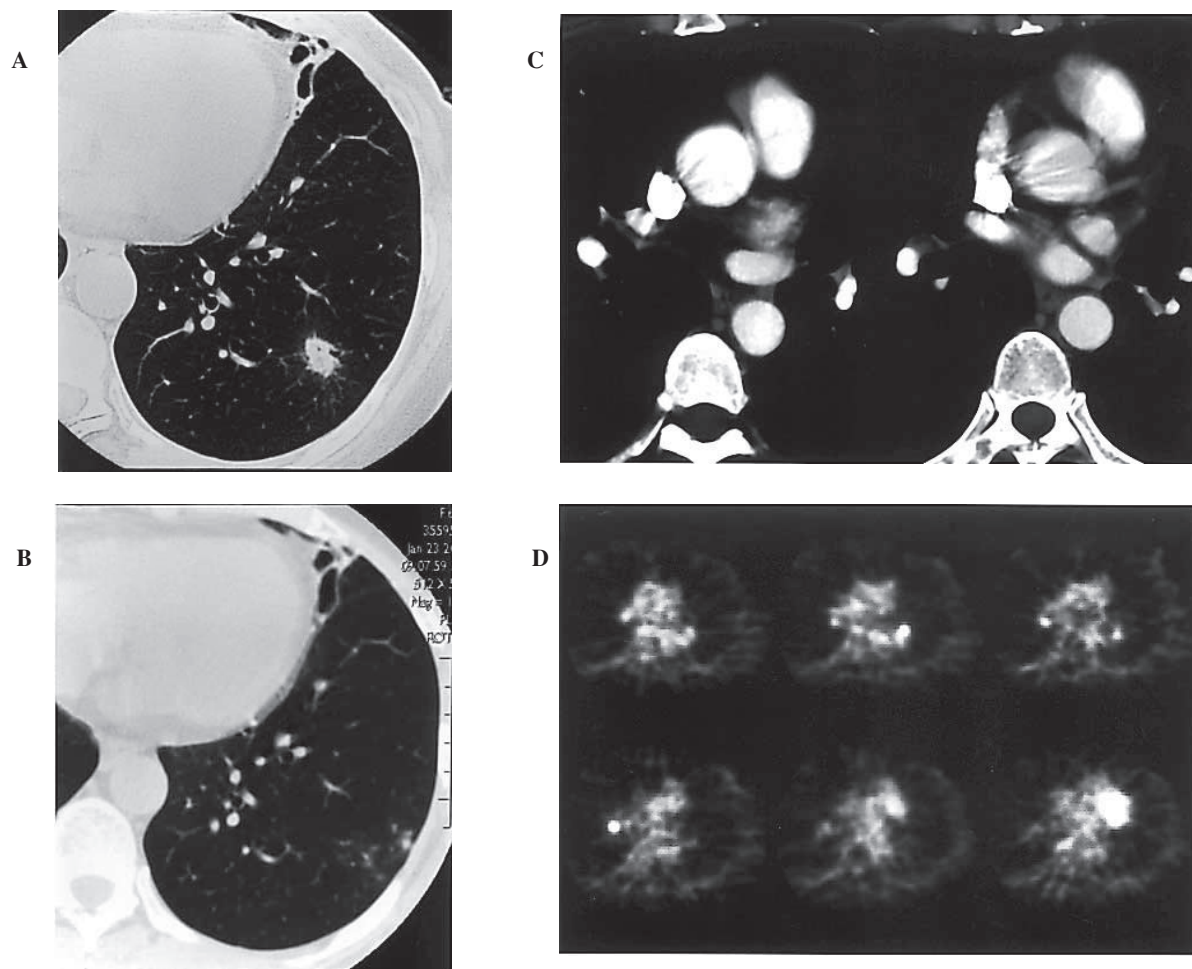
A 64-year-old woman with a left lower lobe nodule that was incidentally detected on low-dose screening CT for lung cancer. A: Transverse CT image shows a 1.3 × 1.0 cm nodule with air bronchogram and irregular margin. B: The nodule had regressed spontaneously on CT 5 months later. C: CT of the hilum shows only small nodes less than 1 cm in short axis. D: Transverse PET scans at the level of the hilum show areas of increased FDG uptake compared to the background level with the SURs between 2.0 and 2.7. This represents a false-positive study with both the visual and SUR criteria.
